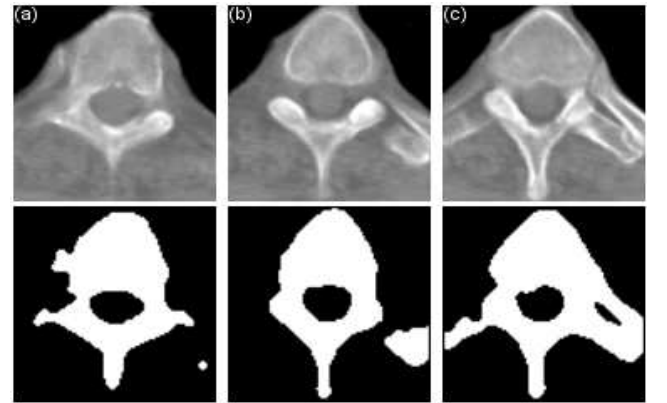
CT thoracic image segmentation of spinal canal: (a) Slice 10. (b) Slice 11. (c) Slice 12.
